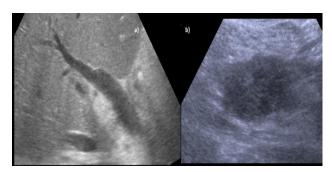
(a) Sonogram showing dilated common bile duct & (b) transverse showing hypoechoic mass lesion at head of pancreas.
